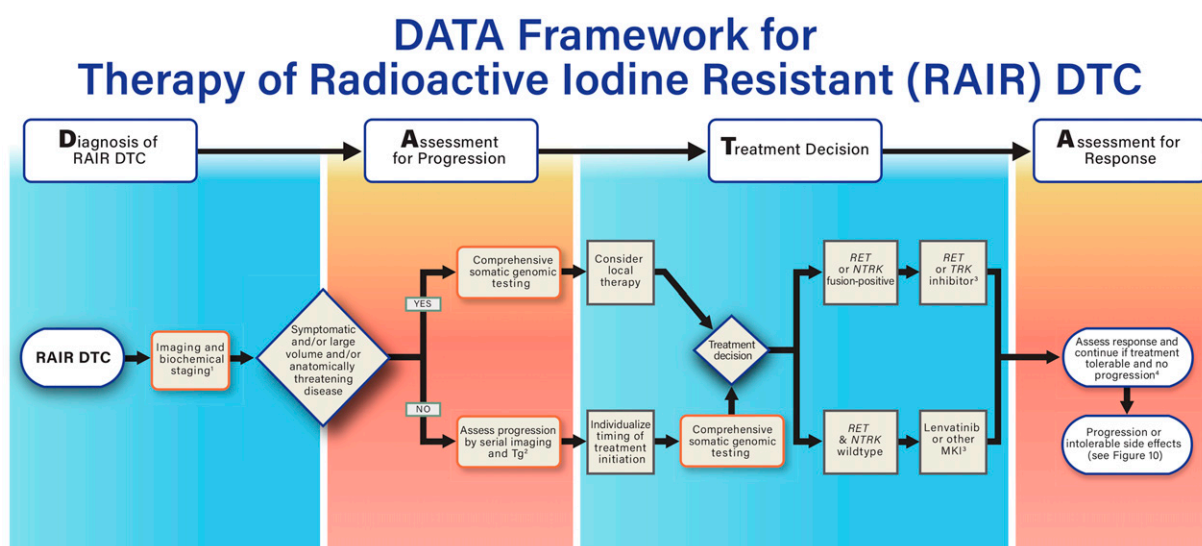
DATA framework for systemic treatment of patients with RAIR unresectable/metastatic DTC. 1) Initial staging may involve CT, MRI, and/or PET/CT. Consider brain MRI to rule out brain metastases. 2) First imaging and Tg monitoring after 2–6 months; timing thereafter is based on rate of progression and/or development of symptoms. 3) First-line gene-specific therapy in most patients with RET or NTRK fusion-positive disease is preferable. Multikinase inhibitors (MKIs) are recommended in general in patients with *BRAF*^{V600E} or RAS-mutated DTC unless based on comorbidities/side effect concerns, patient preference, or clinical trial options. 4) When treatment is discontinued due to treatment related adverse events (TRAE), consider second-line therapy only after disease progression. CT, computed tomography; MRI, magnetic resonance imaging; NTRK, neurotrophic receptor tyrosine kinase; RAIR, radioactive iodine resistant.
